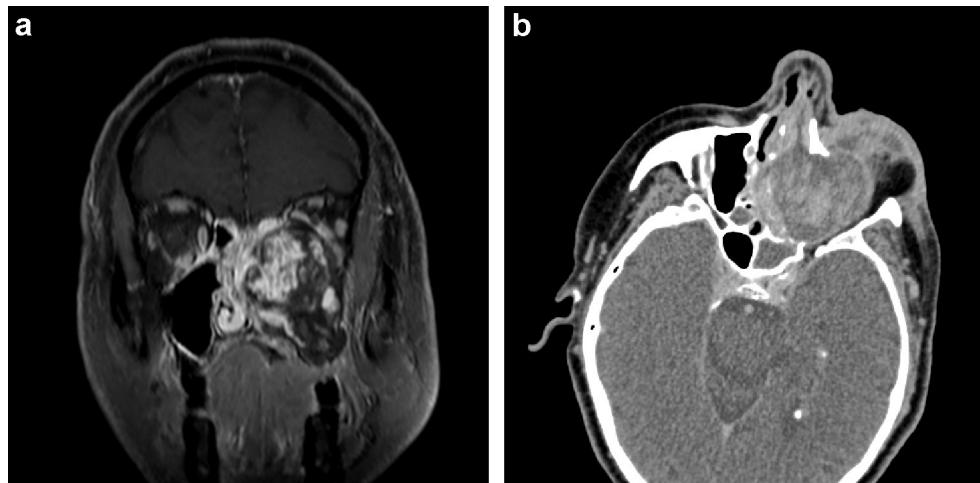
Gadolinium-enhanced MRI coronal slice and CT axial slice of the patient's lesion on admission. All criteria of malignancy are present on the imaging: bone destruction, extensive nature, heterogeneous contrast enhancement, orbital invasion.
